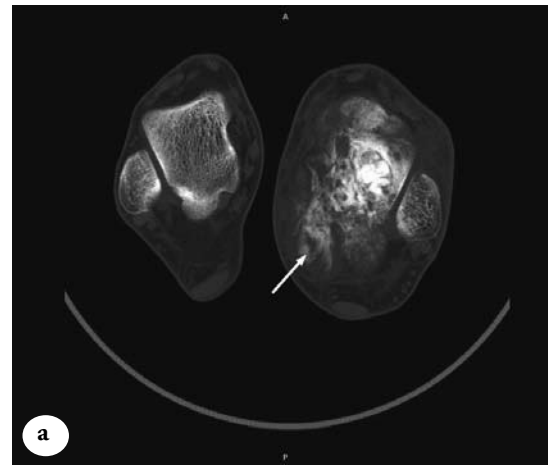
Computed tomography scan of both ankle joints bone window of a) axial section, and b) coronal reformatted showing a destructive bony lesion involving the left talus with new bone formation and bony outgrowth projecting from the postero-medial aspect of the left talus (arrow) and preserved adjacent joints.
